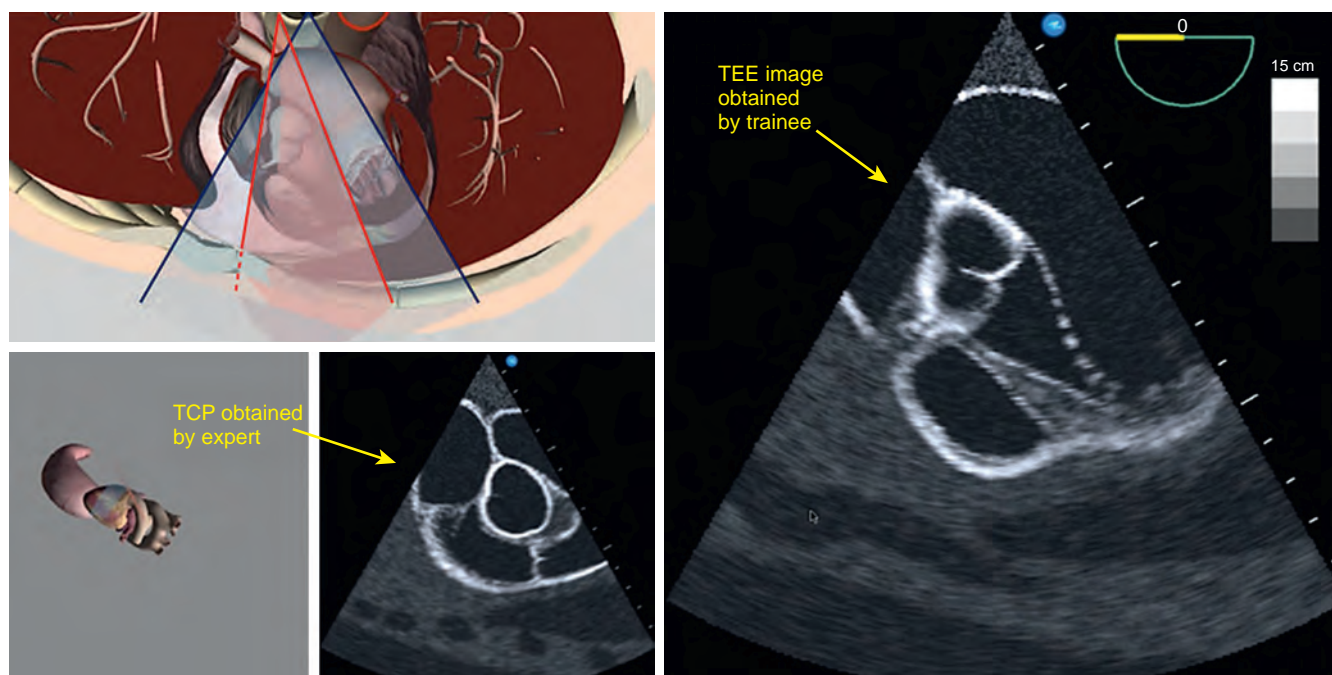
A screenshot showing the different windows visible during a motion tracking acquisition. TCP, Target cut plane; TEE, transesophageal echocardiography.
